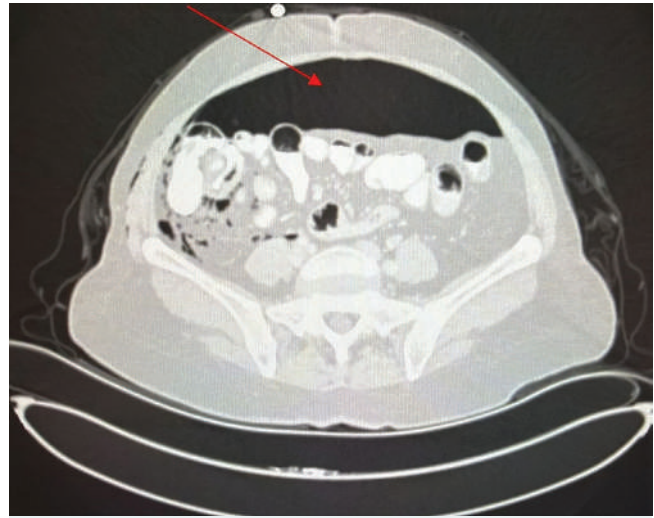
Computed tomography scan after the endoscopic submucosal dissection. (Red arrow) free air in the abdomen.
